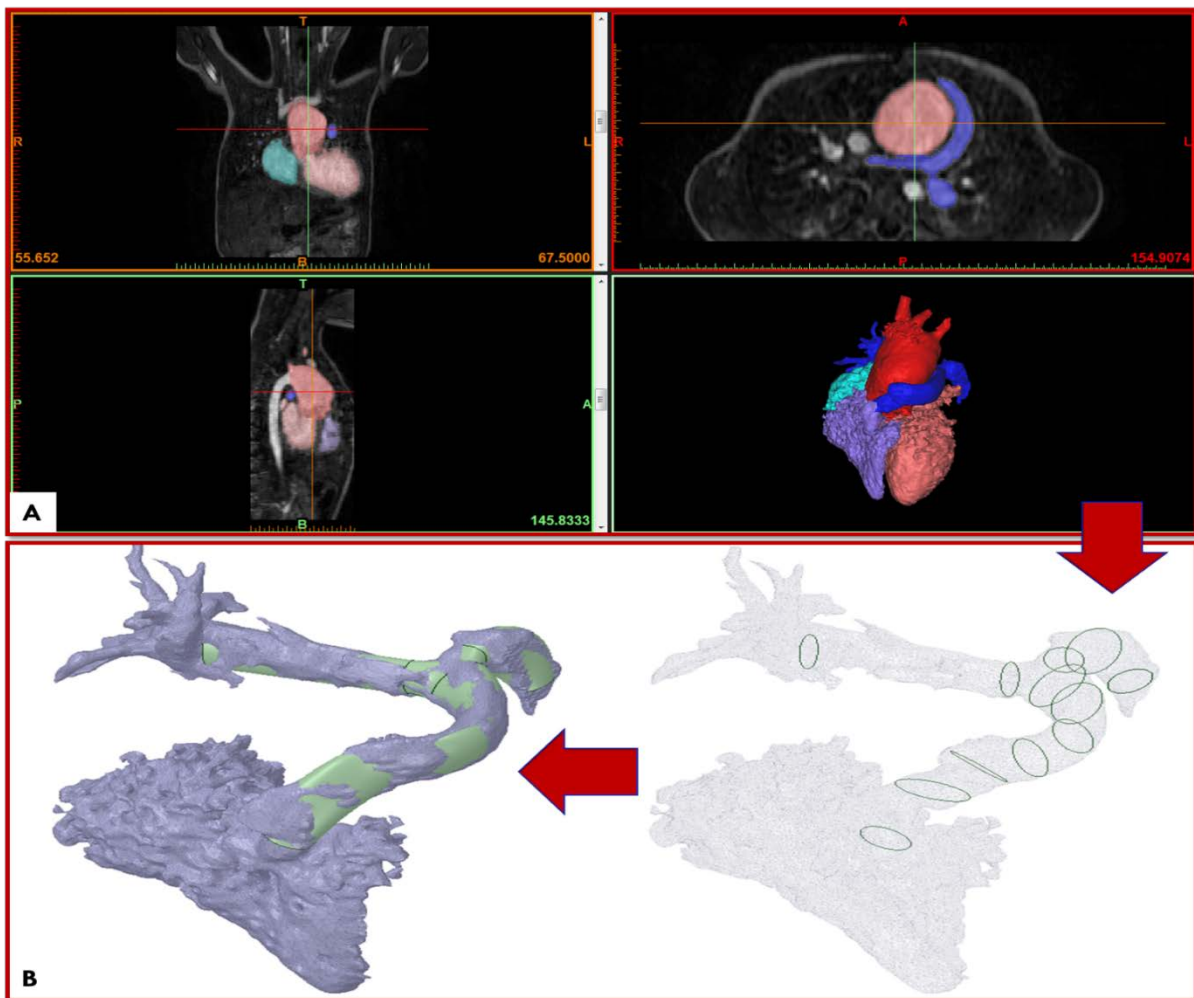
The geometry construction process. (A) Constructing 3D model of the whole heart by performing segmentation on patients' MRI. (B) Constructing conduit's geometry by interpolating between extracted cross-sections. On the right: Extracting crucial cross-sections. On the left: The constructed geometry (green geometry) shows a satisfactory approximation of the original conduit shape obtained from segmentation (grey geometry).
